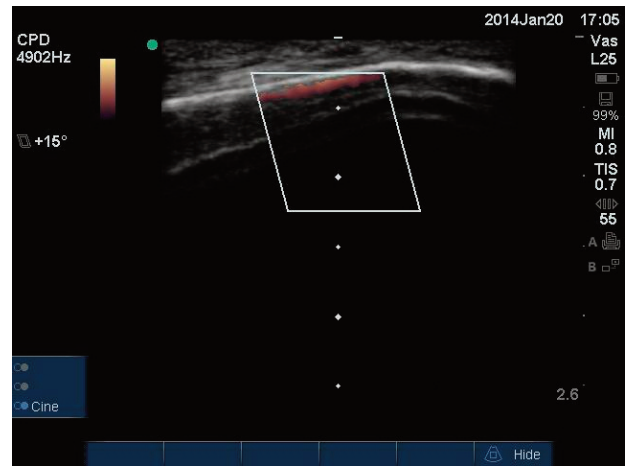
Power Doppler (orange) confirms placement of an intraosseous line within the distal tibia. The bright white line of the tibia cortex (in long axis view) is visualized at the top of the screen, with flow confirmation from a 10cc saline flush immediately distal (below) to the hyperechoic cortex.
